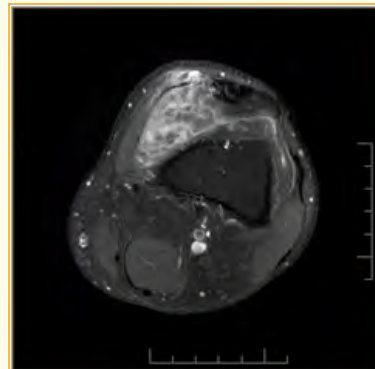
MRI left knee showing fat saturation axial image with fat suppression and fluid collection.
